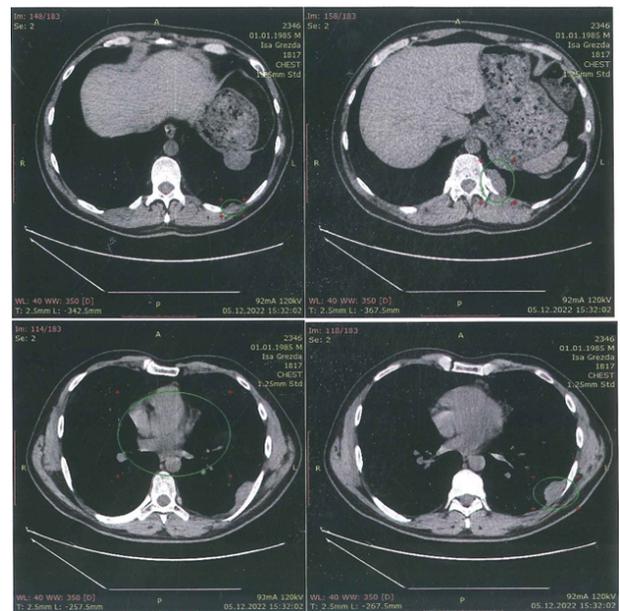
December 2022: Thorax CT after operation.
